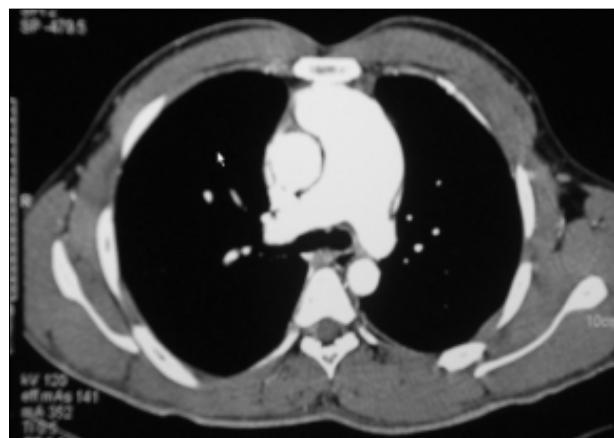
A 3D-Chest CT. Marked aneurysmal dilatation of the main pulmonary artery.
